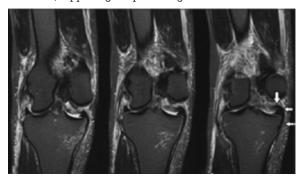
(A–C): MRI coronal STIR images shows, complete tear of the femoral attachment of medial collateral ligament. The torn ligament is seen internally displaced and lying superior to the medial meniscus (arrows)
